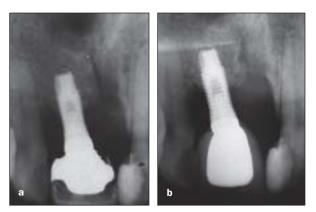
(*a*) Radiograph obtained upon the end of distraction osteogenesis. (*b*) One-year follow-up.
